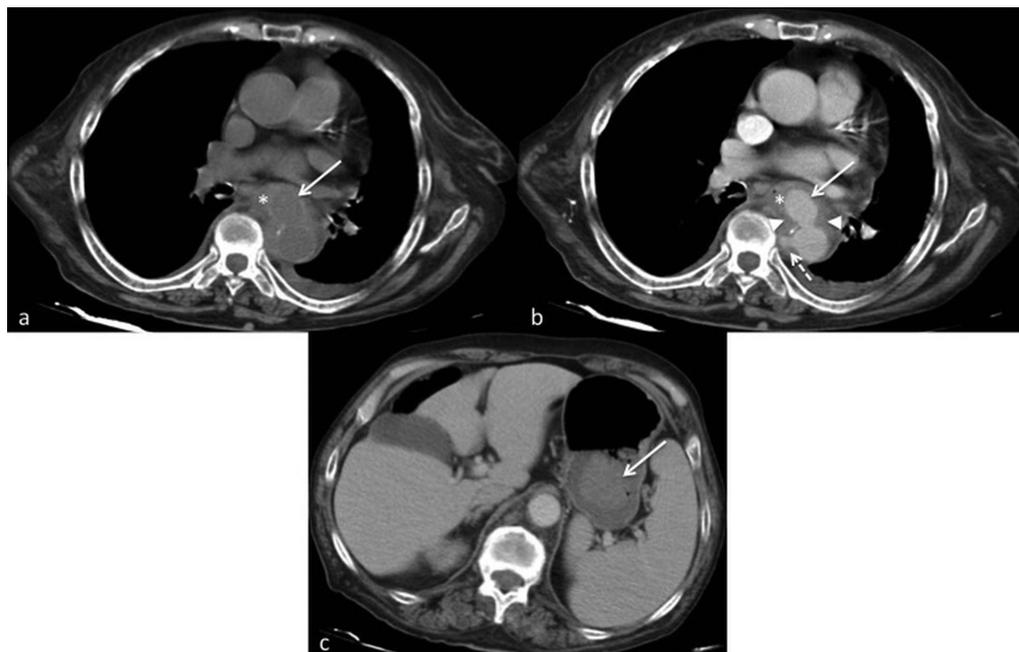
Unenhanced (A) and contrast-enhanced (B) axial thoracic CT images show a ruptured saccular aortic aneurysm (arrow) with fistulisation to the oesophageal lumen (*) that appears filled with contrast material. There is also a penetrating atherosclerotic ulcer (dashed arrow) and peri-aortic fat stranding with loss of the aorta's fat planes (arrowheads). (C) Contrast enhanced abdominal CT image shows a blood clot in the gastric fundus (arrow).
